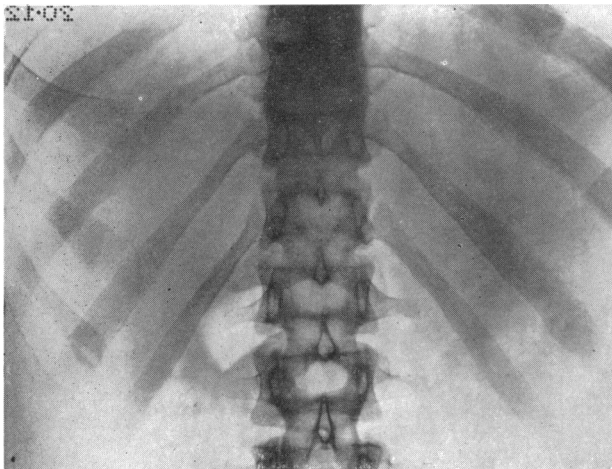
Radiograph of lower ribs on December 20, 1954, showing Looser's zones in ribs R 10 and 11 and L 11. Bones otherwise well calcified and apparently normal.
